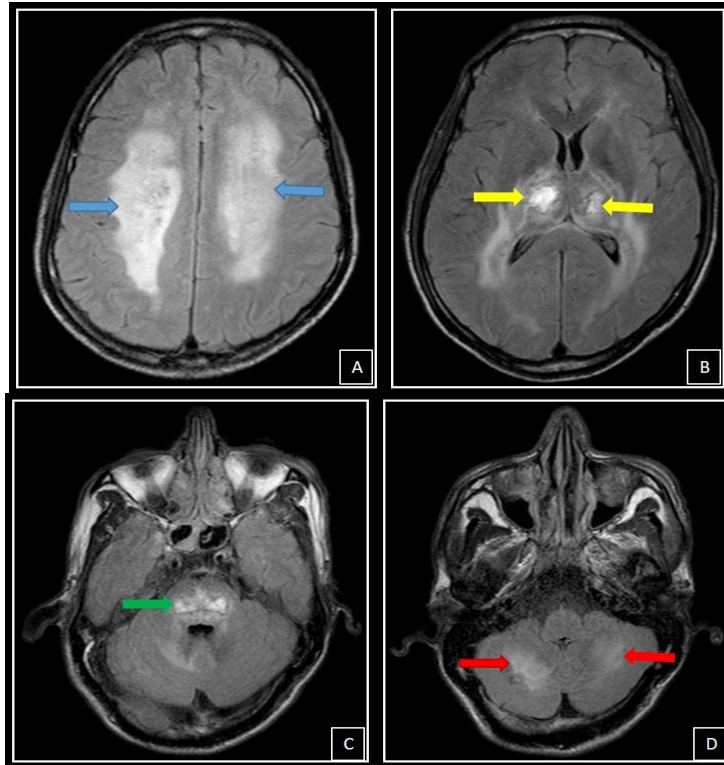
Dengue Encephalitis A, B, C, D: FLAIR.
